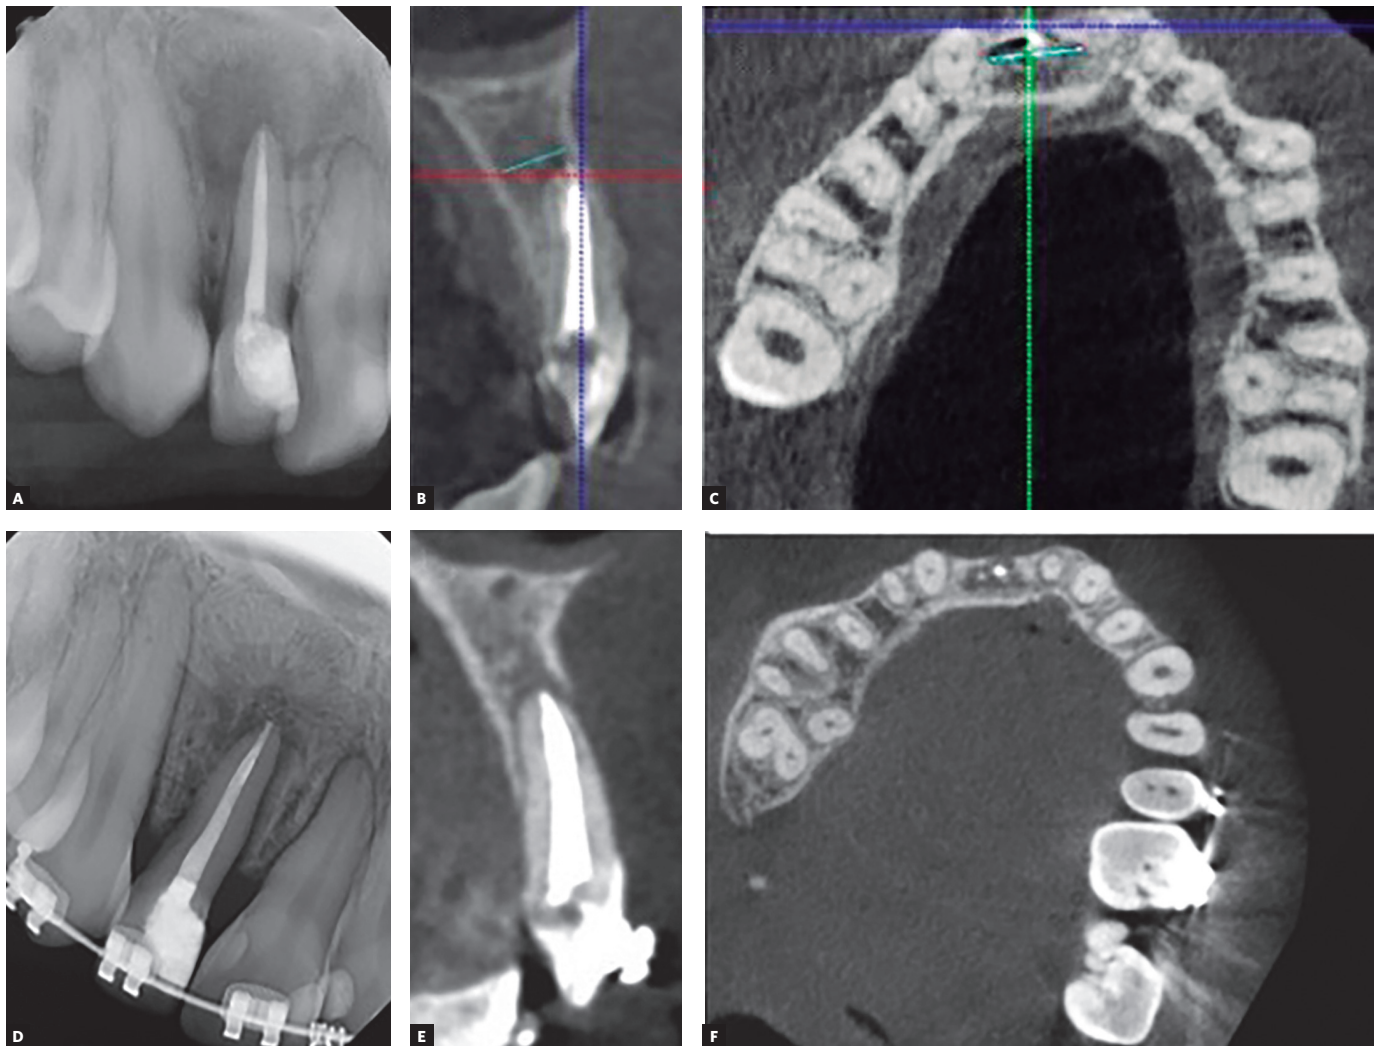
A) Control radiograph at 6 months. B) Cone beam tomography control sagittal section at 6 months. C) Cone beam tomography axial control section at 6 months. D) Control radiograph at 24 months. E) Cone beam tomography control sagittal section at 24 months. F) Cone beam tomography axial control cut at 24 months.
